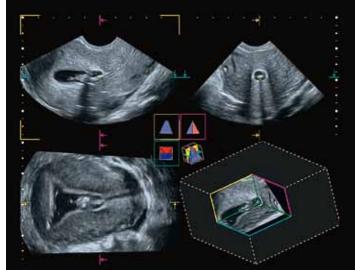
Examples of typical image formats obtained from a single 3D sweep. These can be easily displayed pre- or post storage of acquired volumetric ultrasound data.
